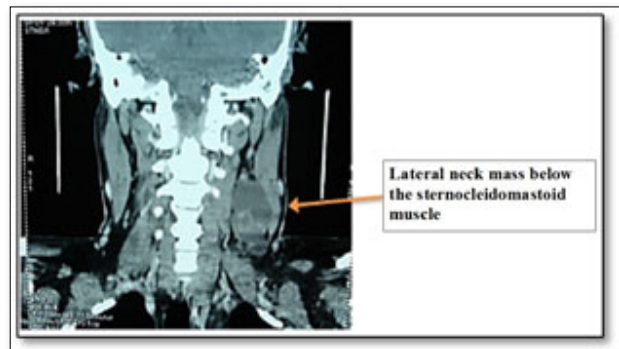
CT scan neck with contrast Coronal View.
